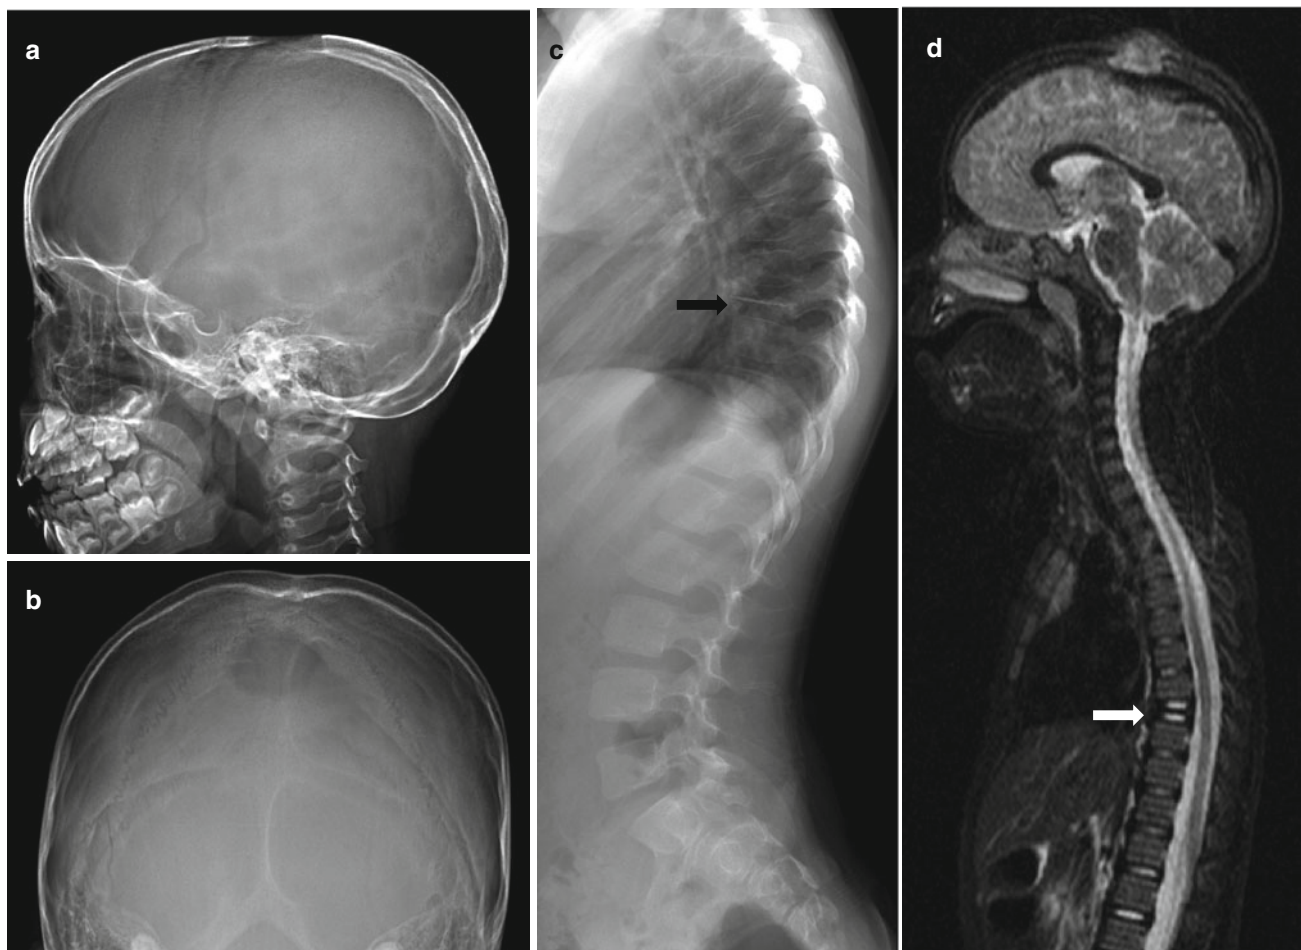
Langerhans cell histiocytosis, polyostotic.* (a, b) Skull lateral and Townes projections show a well-circumscribed, clearly marginated osteolytic lesion in the vertex. (c) Whole-spine lateral radiograph shows complete collapse of the ninth thoracic vertebral
